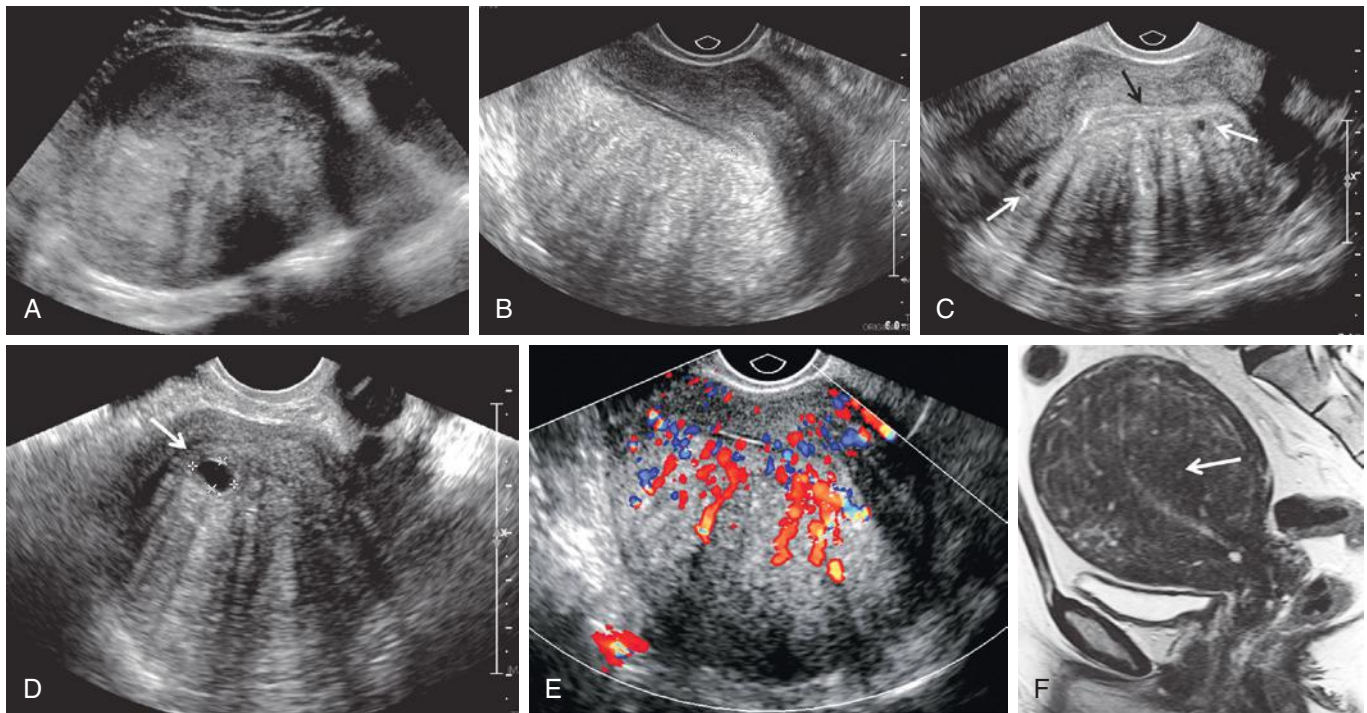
Spectrum of ultrasound findings of adenomyosis. A, Transabdominal sagittal ultrasound image demonstrates enlarged, heterogeneous, globular uterus with asymmetric thickening of the posterior myometrium. B, Transvaginal sagittal scan from a second patient demonstrates asymmetric thickening of the anterior myometrium, with markedly heterogeneous echotexture, hypoechoic linear striations, and shadowing. Endometrial thickness is measured (*calipers*). The uterus is retroverted. C, Transvaginal scan from a third patient demonstrates heterogeneity of the posterior myometrium with small myometrial cysts (*white arrows*) and linear striations. Note linear rays of shadowing in a “comb-like” or “Venetian blind” pattern. The region of abnormal myometrial echotexture is posterior to the endometrium (*black arrow*). D, Larger myometrial cyst (*arrow and calipers*), with asymmetric thickening, heterogeneity of the myometrium, and “comb-like” shadowing. E, Color Doppler sonogram demonstrates diffuse hypervascularity of the asymmetrically thickened posterior myometrium. F, Sagittal T2-weighted magnetic resonance image of a different patient with diffuse adenomyosis demonstrating marked diffuse thickening of the junctional zone (*arrow*) and scattered tiny T2-weighted hyperintense foci.
